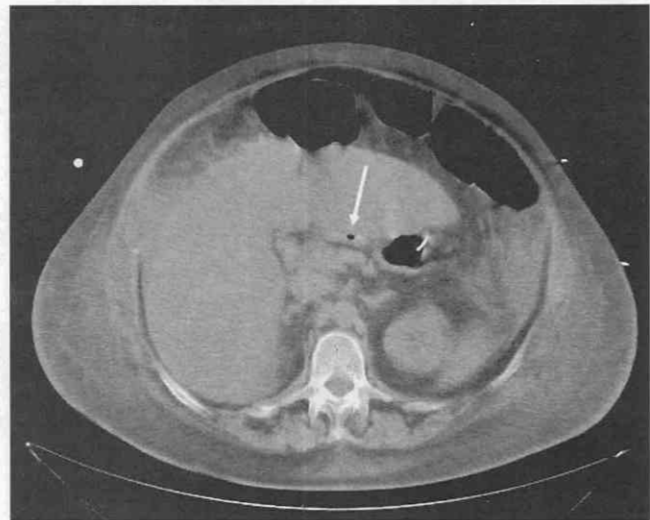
CT scan shows a small collection of contrast medium and air in the lesser sac (arrow) from a small gastric perforation.
